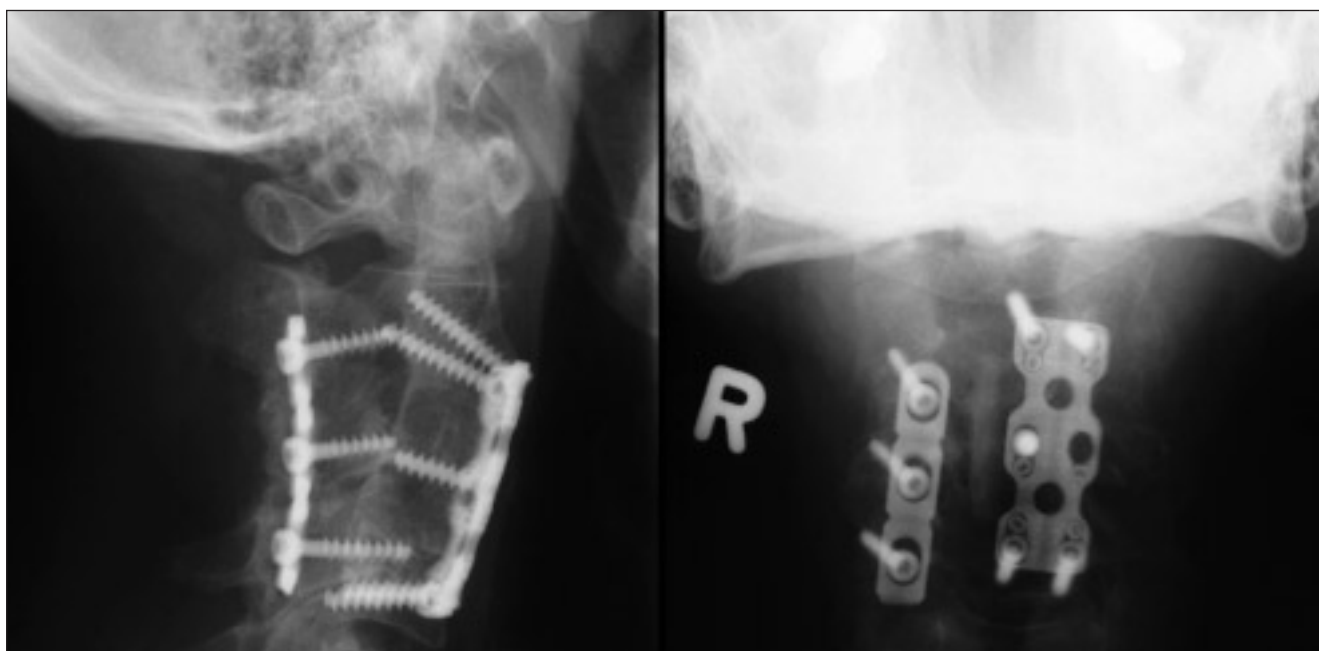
Radiographs 3 months postoperatively show the final bony construct in lateral (left) and anteroposterior (right) projections.
